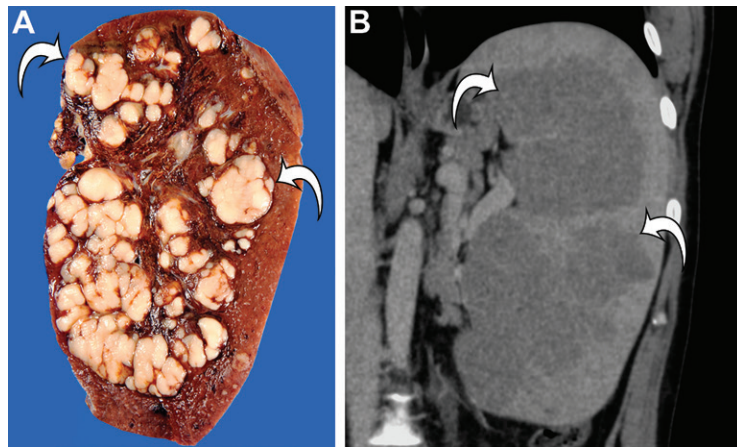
Lymphoma in a 37-year-old man with fatigue, weight loss, early satiety, and massive splenomegaly. (A) Photograph of the sectioned resected enlarged spleen shows near-complete replacement of the splenic parenchyma with innumerable well-defined, solid, tan nodules (arrows). (B) Coronal contrast-enhanced CT image best shows splenomegaly and innumerable homogeneously hypoattenuating nodules (arrows), which are hypoenhancing to the residual normal spleen.
